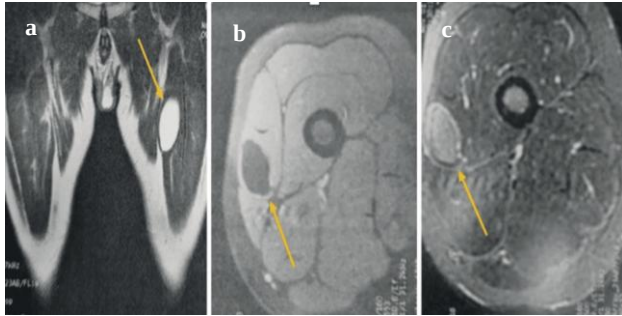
(a-c): MRI of the thigh, showing a well-defined subcutaneous mass with lobulated margins in the anterior thigh region, measuring 7 cm in length and 3 cm in width with enhancement after gadolinium injection.
